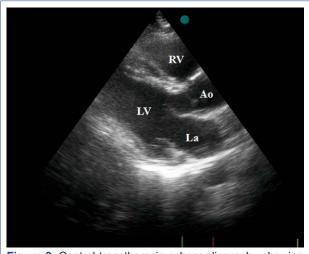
Control transthoracic echocardiography showing no residual pericardial effusion.
